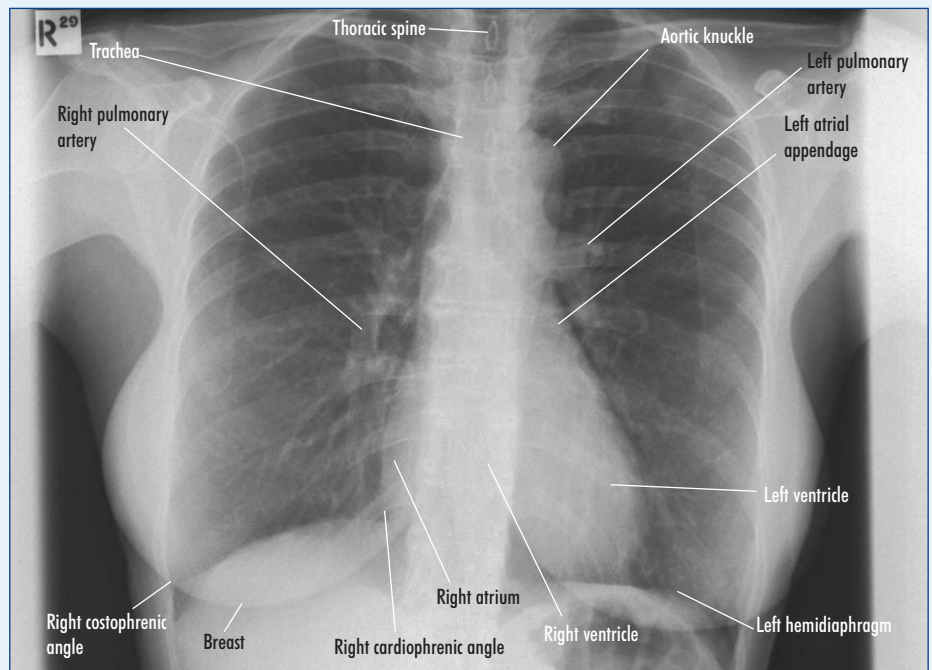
Normal posteroanterior chest radiograph with annotations.
